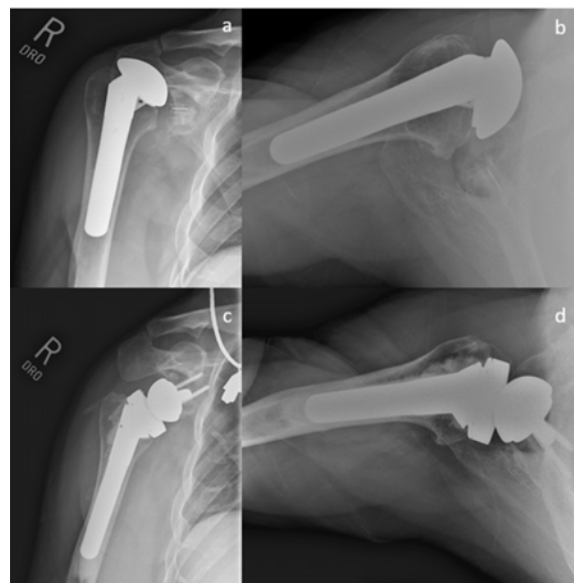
Pre-operative anteroposterior (a) and axillary (b) radiographs of right shoulder demonstrate decentered humeral head. Post-operative anteroposterior (c) and axillary (d) radiographs were demonstrated after conversion to reverse total shoulder arthroplasty.
